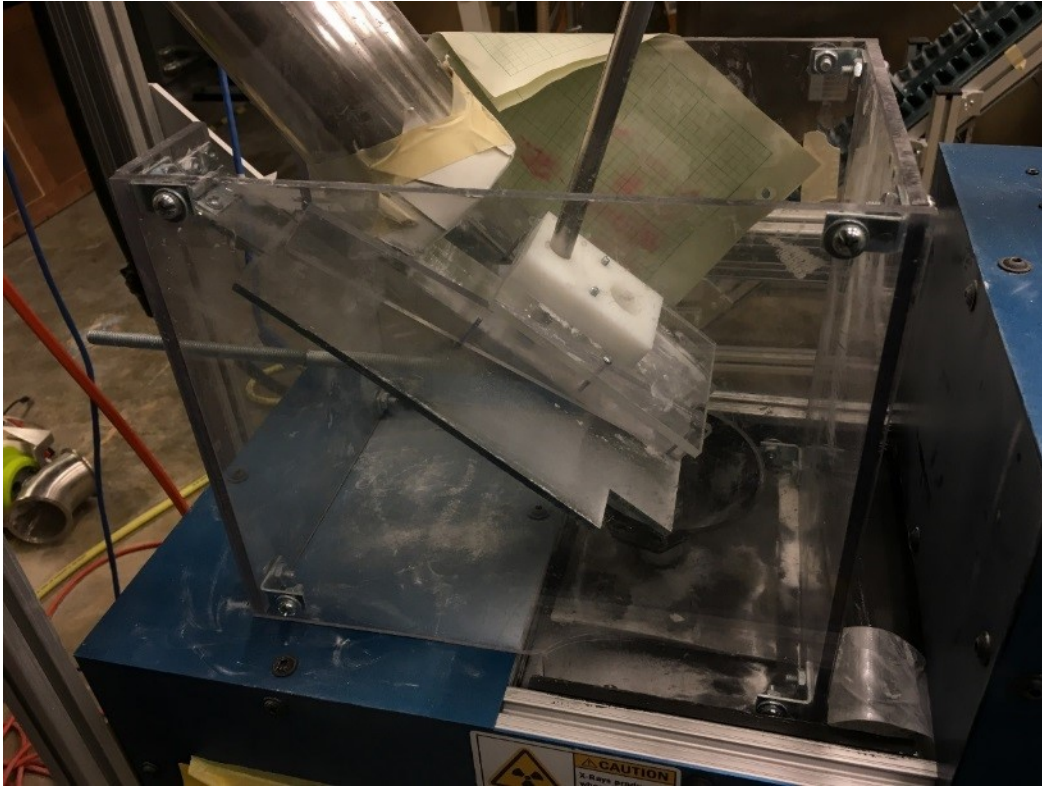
Custom physical interface for implementing the X-ray sensor in the OSD-CM process
